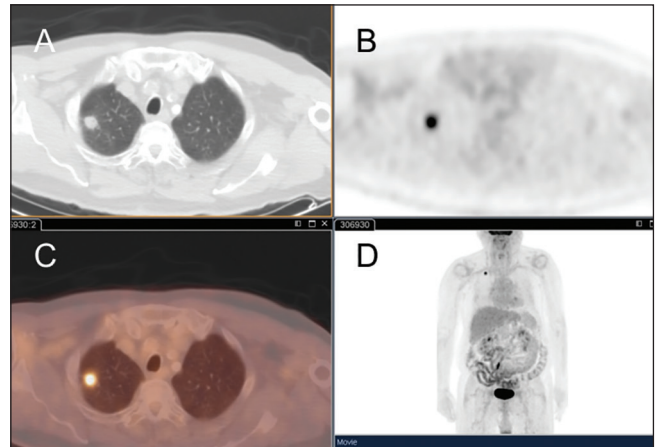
Noncavitary non-small cell lung cancer. Fluorodeoxyglucose positron emission tomography/computed tomography, axial computed tomography (a), positron emission tomography (b), fused positron emission tomography-computed tomography (c), and maximum intensity projection image (d) of a 77-year-old man with a history of adenocarcinoma of the right upper lung lobe. The lesion measured 1.6 cm × 1.4 cm with standardized uptake value of 7.6 and standardized uptake value ratio of 2.8. The patient underwent right upper lobectomy, and the biopsy of hilar nodes was negative for malignancy, T1N0M0, Stage I. He died 44 months after surgical resection of the primary
